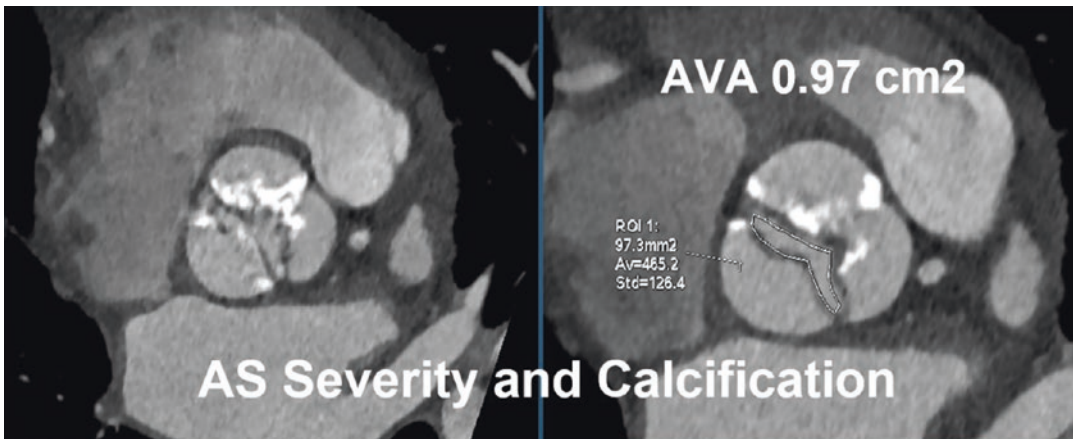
CT images of severe calcific aortic stenosis. Left image during ventricular diastole with closed trileaflet valve. Right image shows reduced opening and a severely reduced area of <1 cm²
